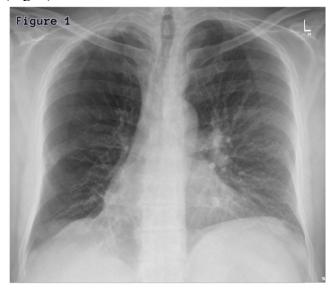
Chest X-ray PA view showing relatively hyperlucent right lung, decreased vascular markings in right lung and tiny cystic-like areas in the right lower zone.
